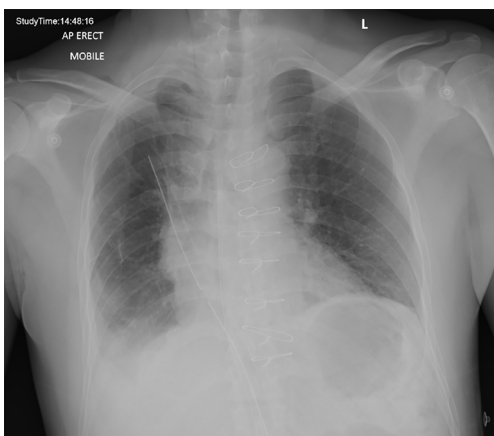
Chest X-ray of patient following mediastinal mass resection.
